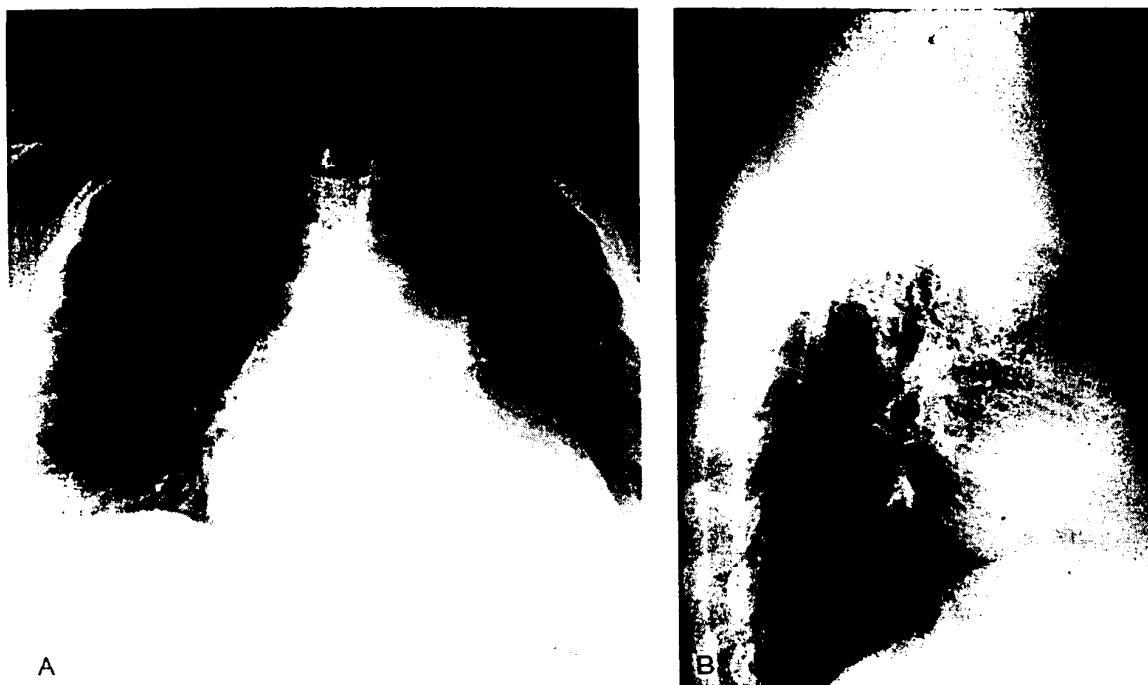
Frontal and lateral chest roentgenograms of 24-year-old woman with pulmonary hypertension associated with the CREST syndrome showing dilated pulmonary outflow tract and widened cardiac silhouette from right ventricular enlargement.
